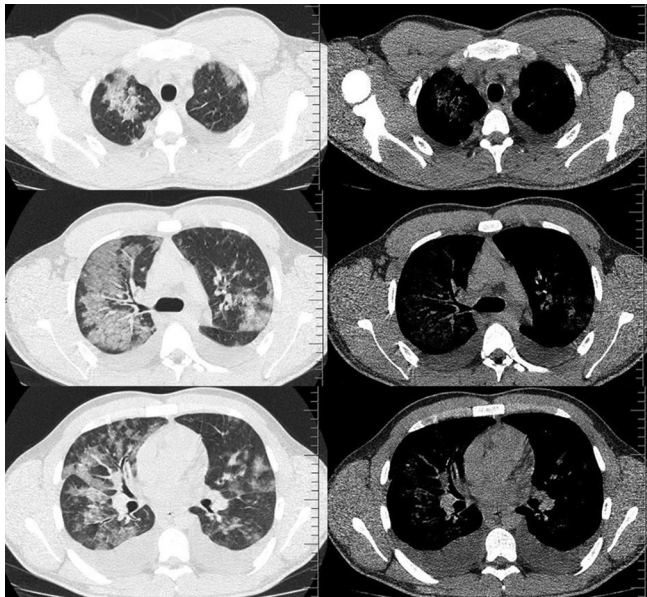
High-resolution computed tomography scans included bilateral, random, and patchy ground-glass opacities, and also small bilateral pleural effusions
